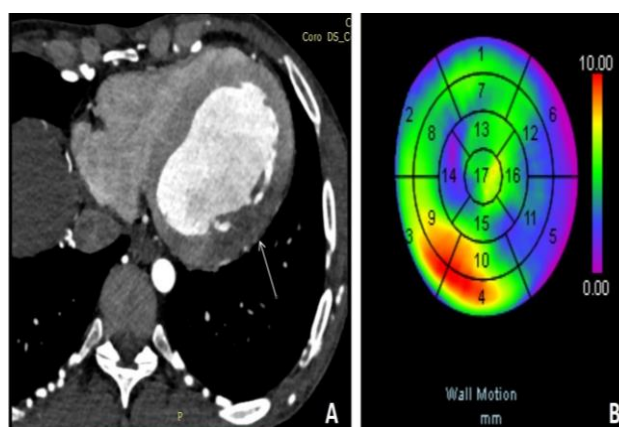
(A-D): CT coronary angiography showing high grade stenosis of proximal obtuse marginal artery (arrow), normal left circumflex, left anterior descending and right coronary artery.
